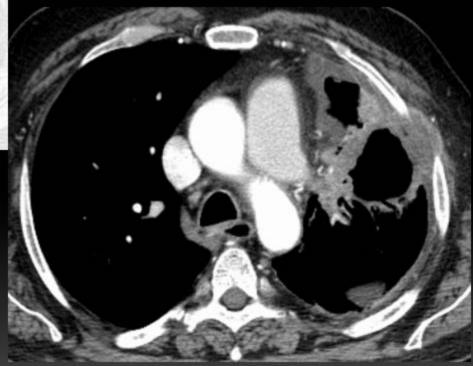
Man, 58 years old, with chest pain and hemoptysis. Thoracic CT shows a thick walled cavitation in the anterior segment of the left upper lobe. It invades the ipsilateral pleura and thoracic wall. Loculated pleural effusion is seen adjacent to the cavitated lung neoplasm.
